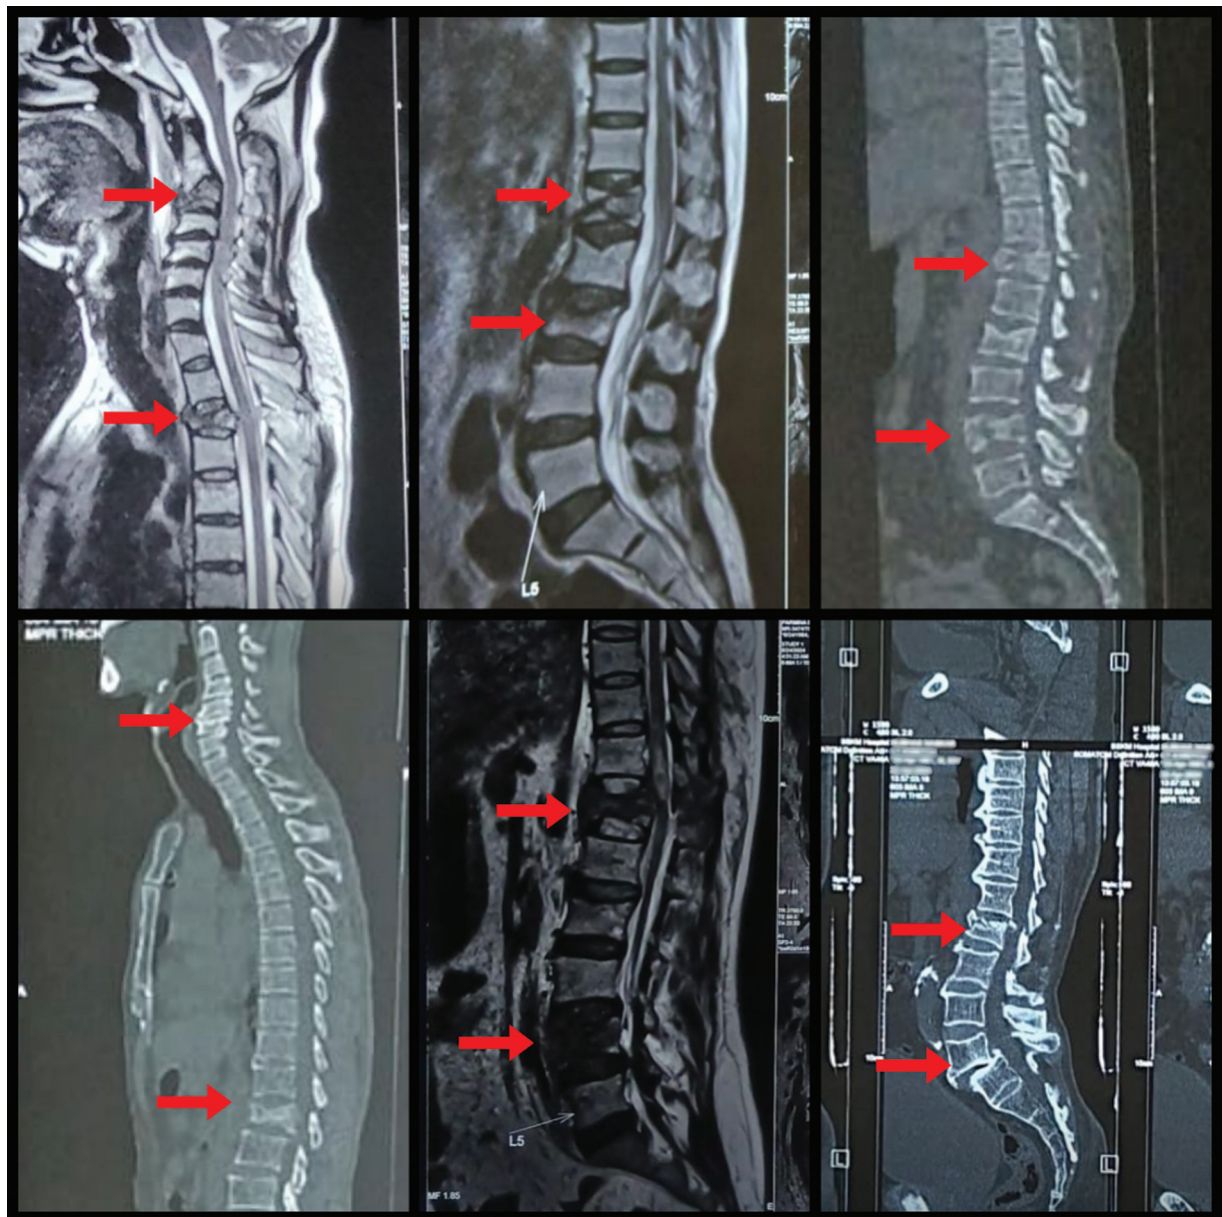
Various types of noncontinuous spinal fractures. The arrows indicate the level of injury in the spine as seen in CT or MRI images.
